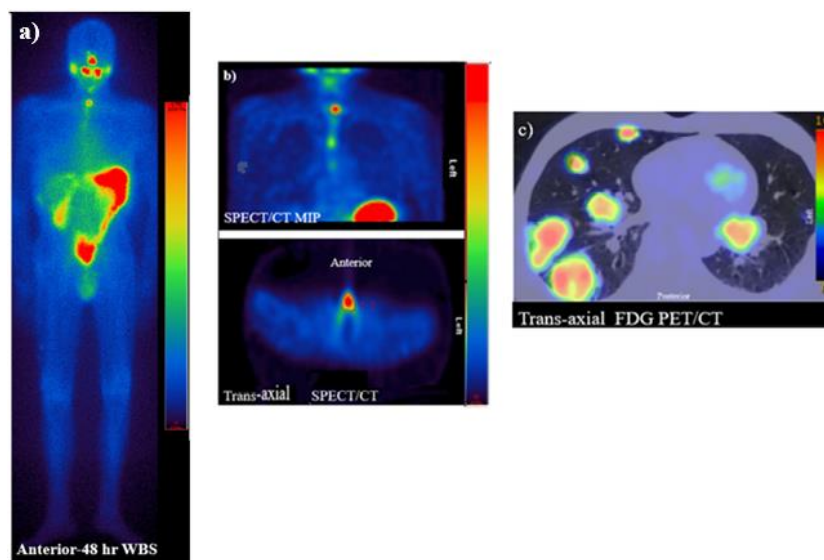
DTC patient Thyca-2 received 5780 MBq of ^{131}I for ablation therapy. 48-hour imaging showed remnant thyroid tissue uptake and no evidence of iodine-avid metastatic disease. a) WBS anterior view and b) SPECT/CT, c) FDG-PET/CT shows evidence of FDG-avid lung metastases.
